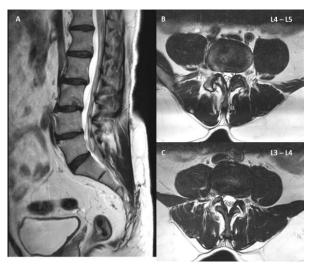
A 45-year-old male presented with right lower limb radiculopathy and magnetic resonance imaging lumbar spine (A) sagittal and axial view (B) L4-L5, (C) L3-L4 showing right L4-5 foraminal disc bulge.
